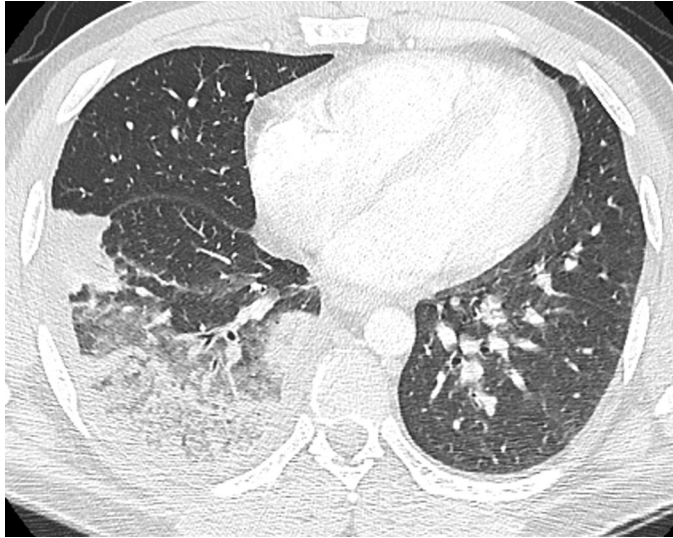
■ Axial computed tomography (CT) slice through lower chest. Localized interstitial and airspace opacities in the right lower lobe after drainage of the pleural fluid collection. Small pleural effusion persists.
